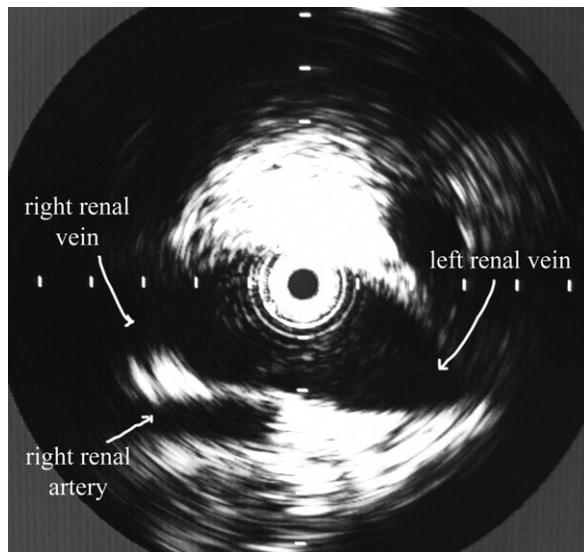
An intravascular ultrasound image shows the vena cava at the lower edge of the origin of the renal veins with the right renal artery crossing posteriorly. This is the desired location to which the filter delivery sheath tip should be positioned for ideal filter placement.
